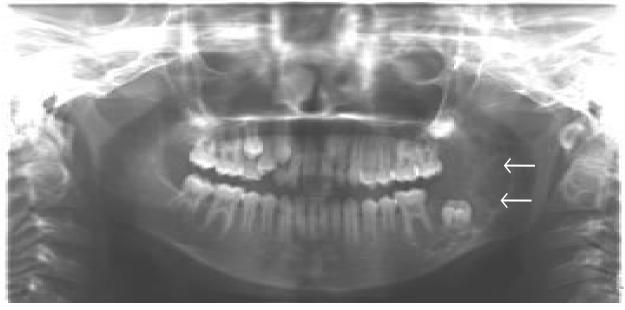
Panoramic radiograph showing multilocular radiolucent lesion with faint curved septae in left ramus-body of mandible.
